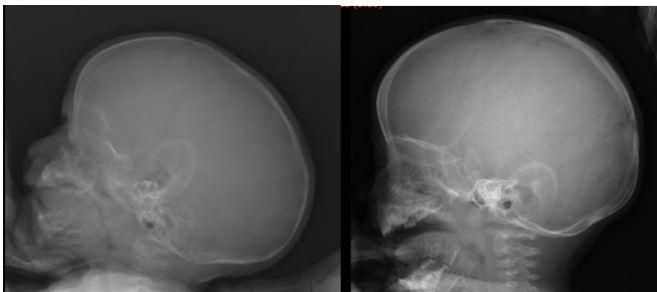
Preoperative and postoperative lateral view of plain radiograph of patient operated at 6 months for scaphocephaly.
